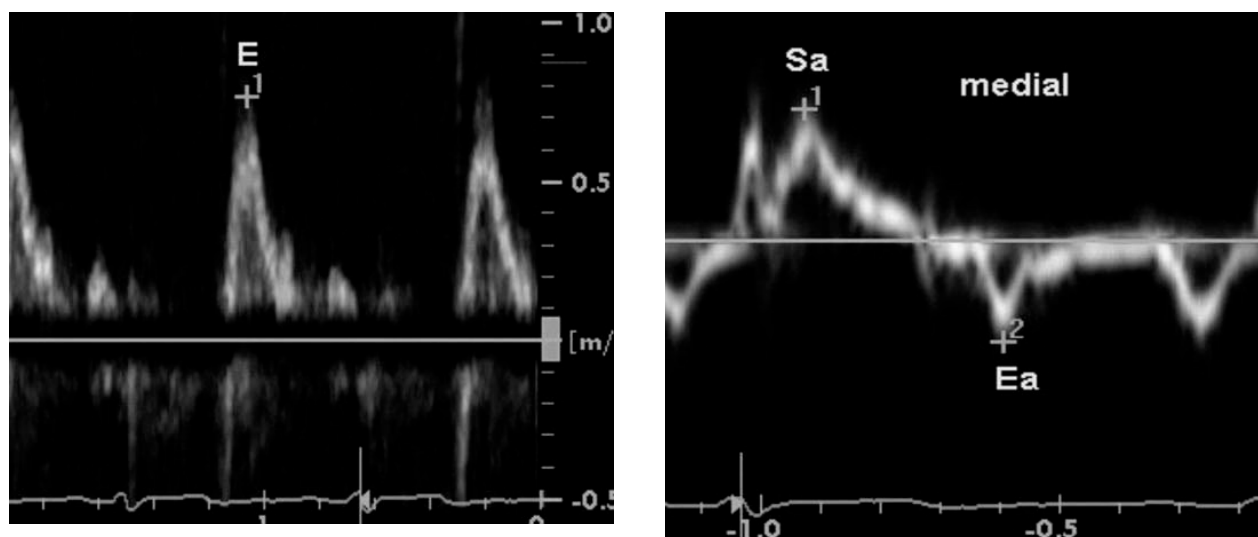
Bedside measurements of spectral Doppler peak early transmitral inflow (E) velocity (panel a) and spectral tissue Doppler peak early diastolic (Ea) velocities, respectively peak systolic (Sa) velocities, at the medial (panel b) and lateral (panel c) corners of mitral annulus. The average of the velocities from medial and lateral mitral annulus was used to calculate the E/Ea ratio.
